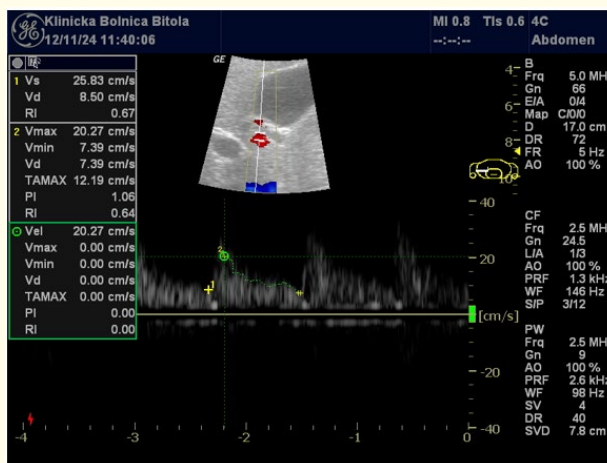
Doppler ultrasonography of hepatic artery in a 59-year-old male with COPD and NAFLD: Hemodynamic assessment.
